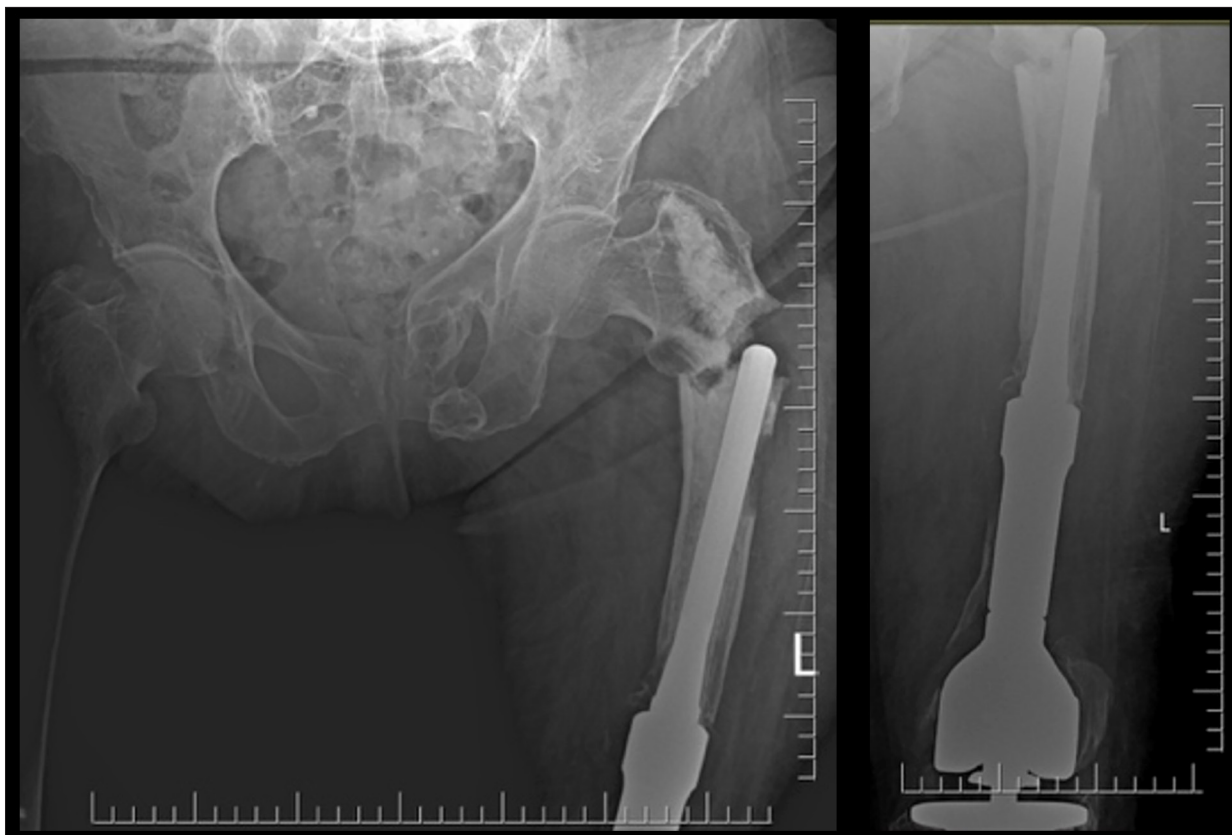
Admission radiograph demonstrating a displaced subtrochanteric periprosthetic femoral fracture. The tip of the knee prosthesis stem is visible.
